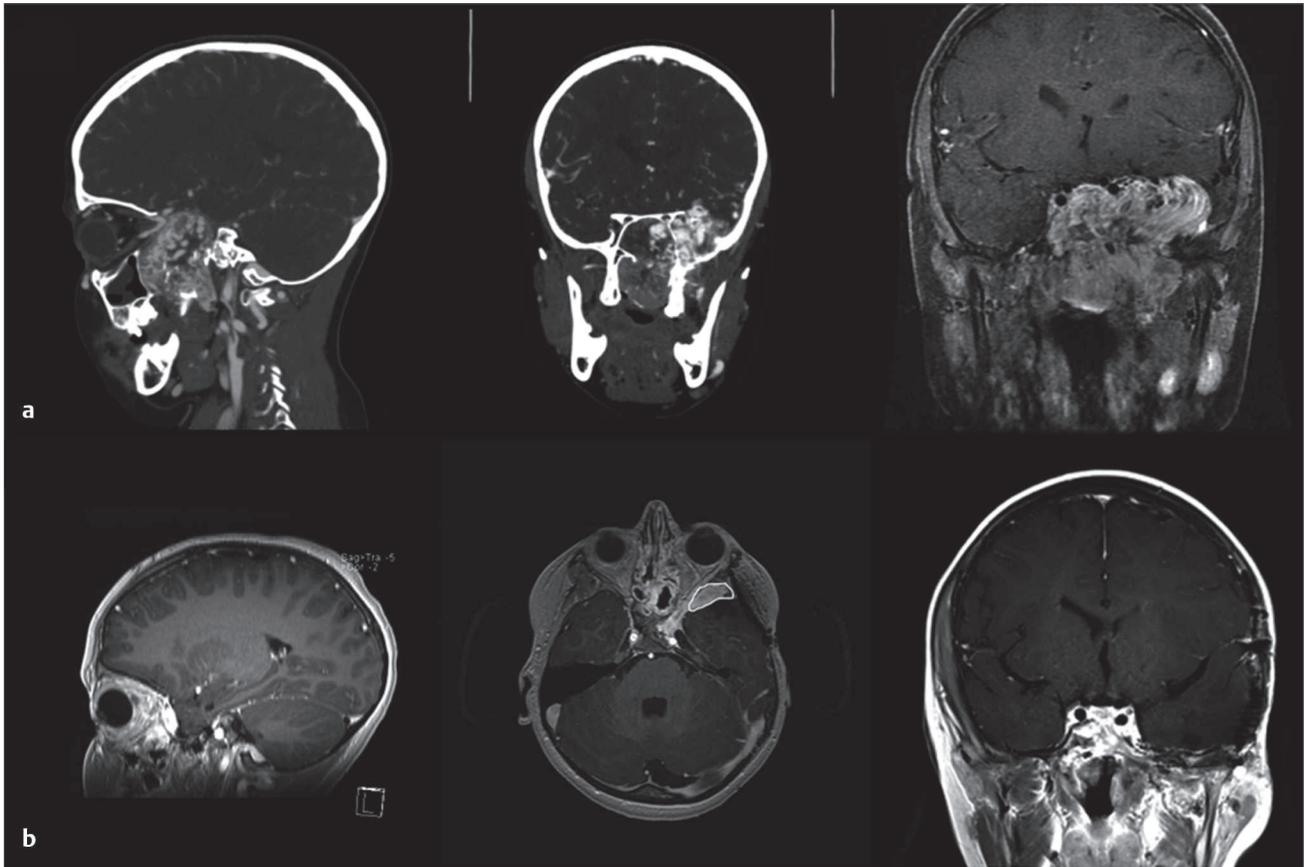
(a) Coronal and sagittal reconstructions from pre-embolization CT angiography and coronal postcontrast T1-weighted imaging of a juvenile nasopharyngeal angiofibroma with intracranial extension that was resected in three stages: a combined pterional and endoscopic endonasal approach and two endoscopic endonasal approaches. (b) Sagittal, axial, and coronal postcontrast T1-weighted images 1 year after resection. On the axial image, a small residual superolateral to the orbit is circled in white. This has remained stable.
